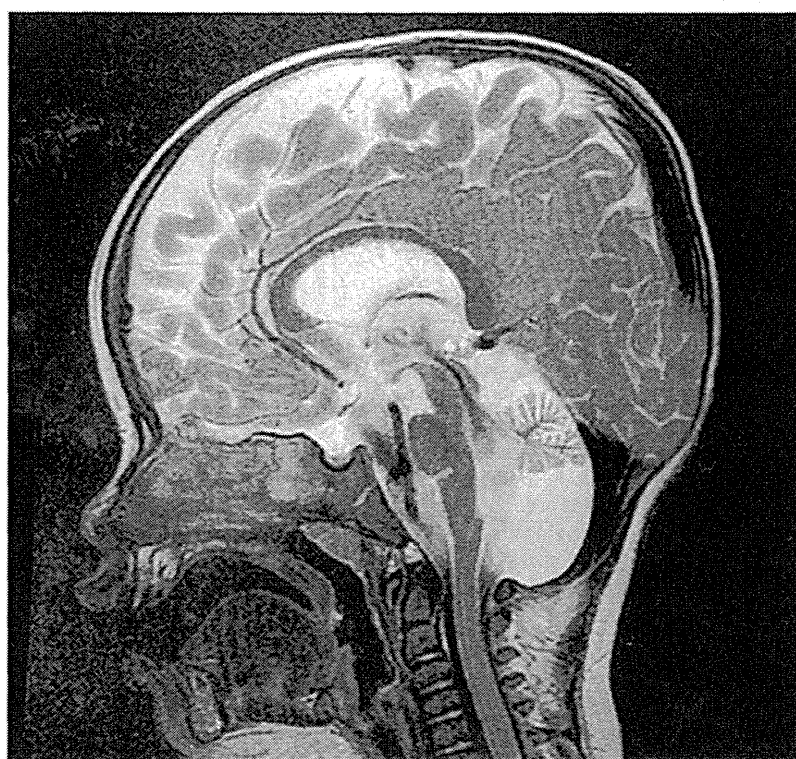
Sagittal midline T2-weighted MR image of patient 5, demonstrating cerebellar atrophy of the vermis.
